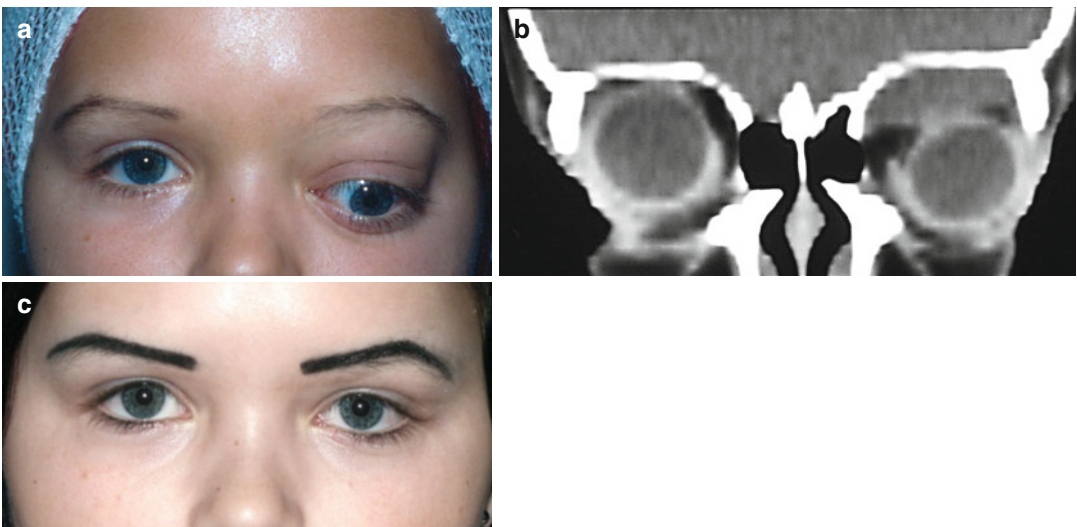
(a–c) Traumatic hematoma in the left orbit. Facial photography before the surgery, CT image, facial photo after the surgery
